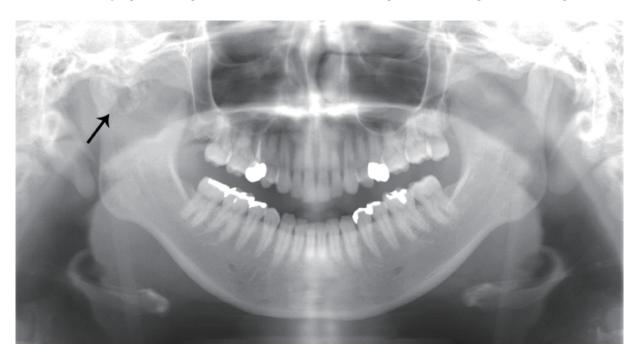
Panoramic X-ray showing calcifying changes of the right side around the condylar head. (Arrow)
